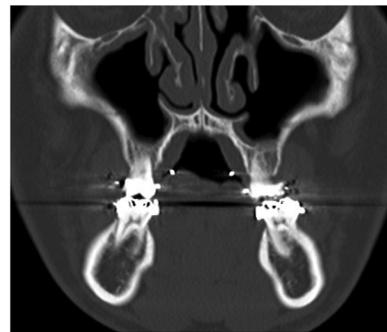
Coronal computed tomography before orthognathic surgery. There was no cystic lesion in maxillary alveolus.
